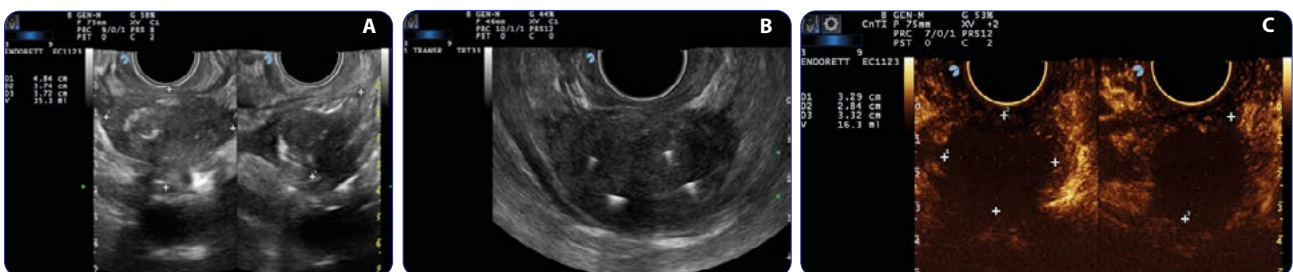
a) Basal transrectal ultrasound. The prostate has a volume of approximately 35 cc with an inhomogeneous echostructure in the adenomatous base; b) The transversal scan of the prostate shows the optical fibres inserted; c) Final transrectal ultrasound with echo-amplifying contrast medium (SonoVue). The avascularised hypoechogenic area measures approximately 16 cc (about 46% of the initial prostatic volume).
